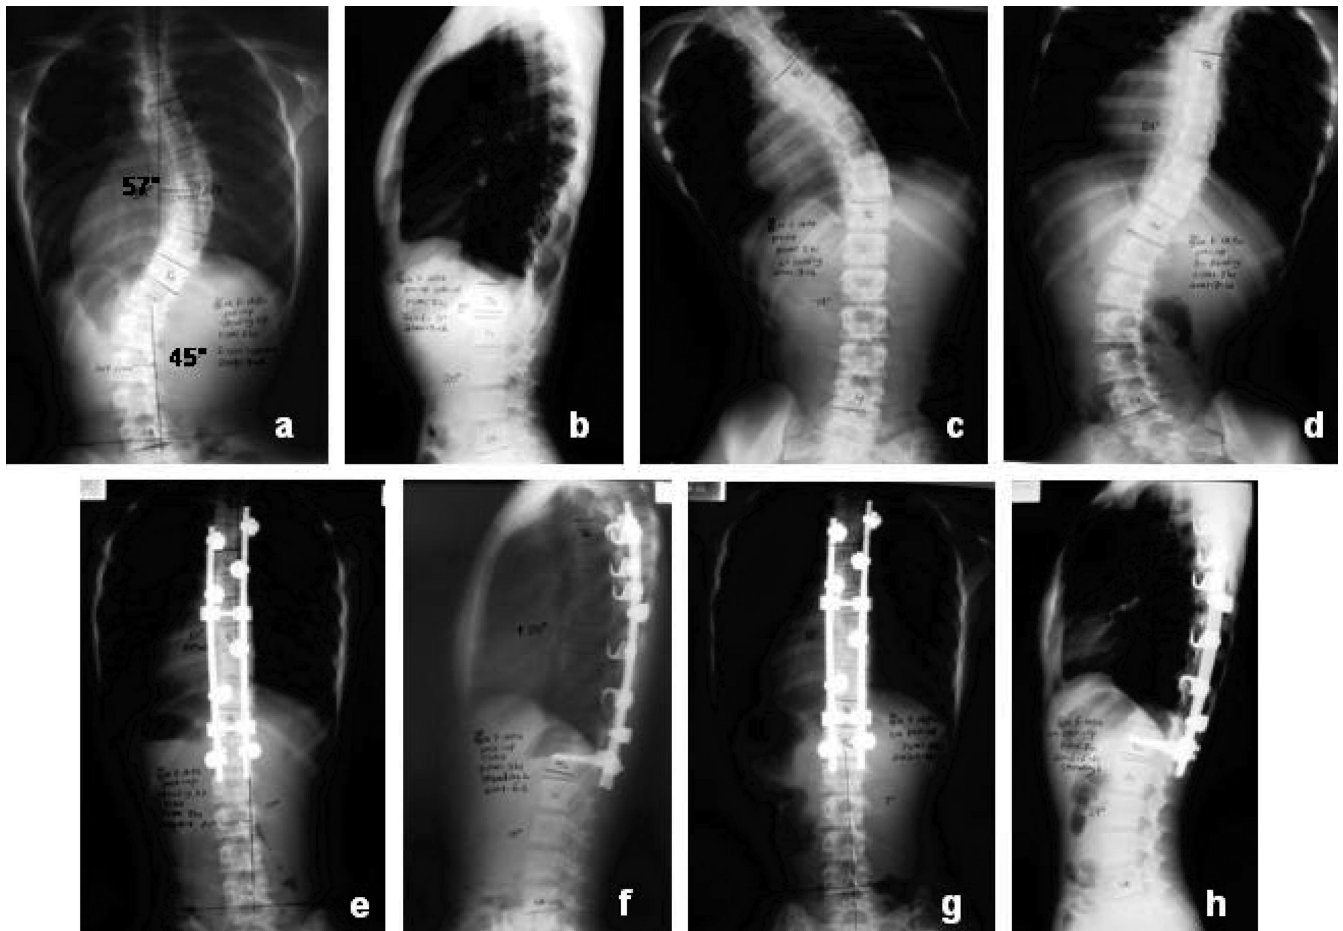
A 14-year-old-female with PUMC type IIb1. a, The thoracic curve was 57° and the lumbar curve 45°, lumbar apical vertical translation was 19 mm, while apical vertebral rotation (AVR) was grade I. b, No thoracolumbar kyphosis was found. c, d, The supine bending films showed the lumbar flexibility was more than 70%. e, f, After selective posterior thoracic fusion with Texas Scottish Rite Hospital (instrumentation), both coronal and sagittal balance were well maintained. g, h, The radiograph at 6-month follow-up shows that the corrected thoracic curve and kyphosis are still well maintained.
